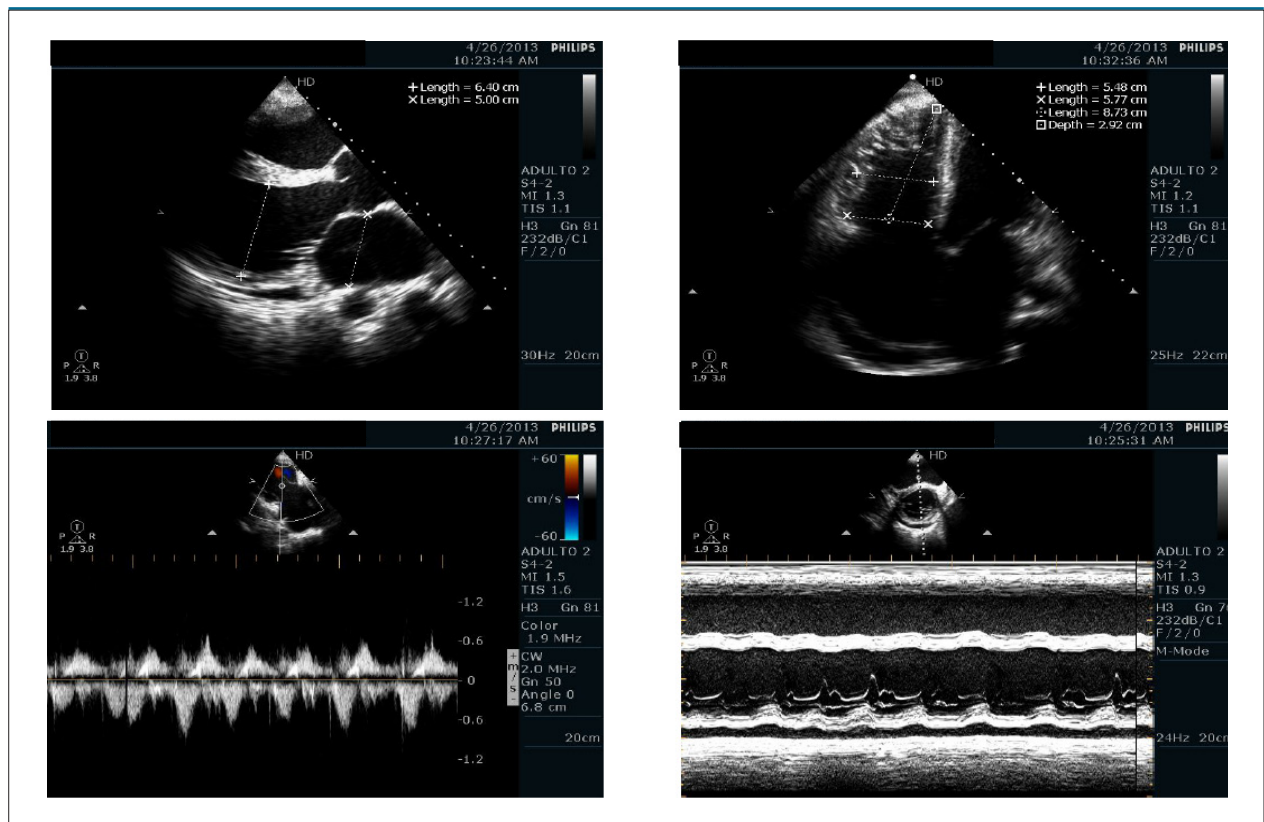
Transthoracic echocardiogram (April 2013): biventricular and biatrial enlargement.
